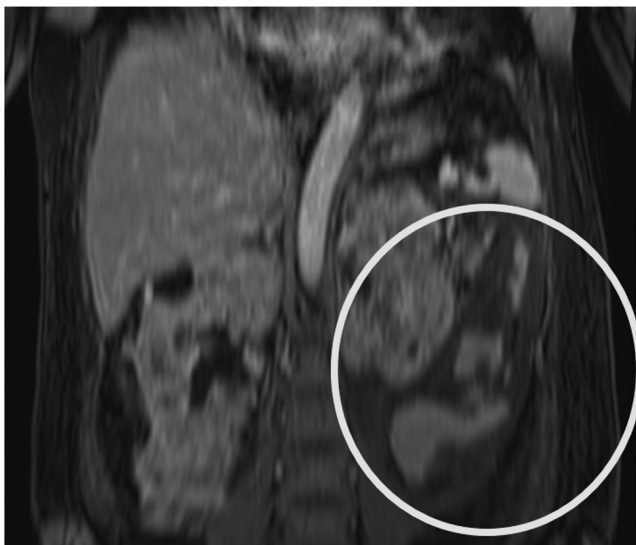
Contrast-enhanced magnetic resonance imaging of the abdomen (Coronal View). Subcapsular perirenal hematoma.
